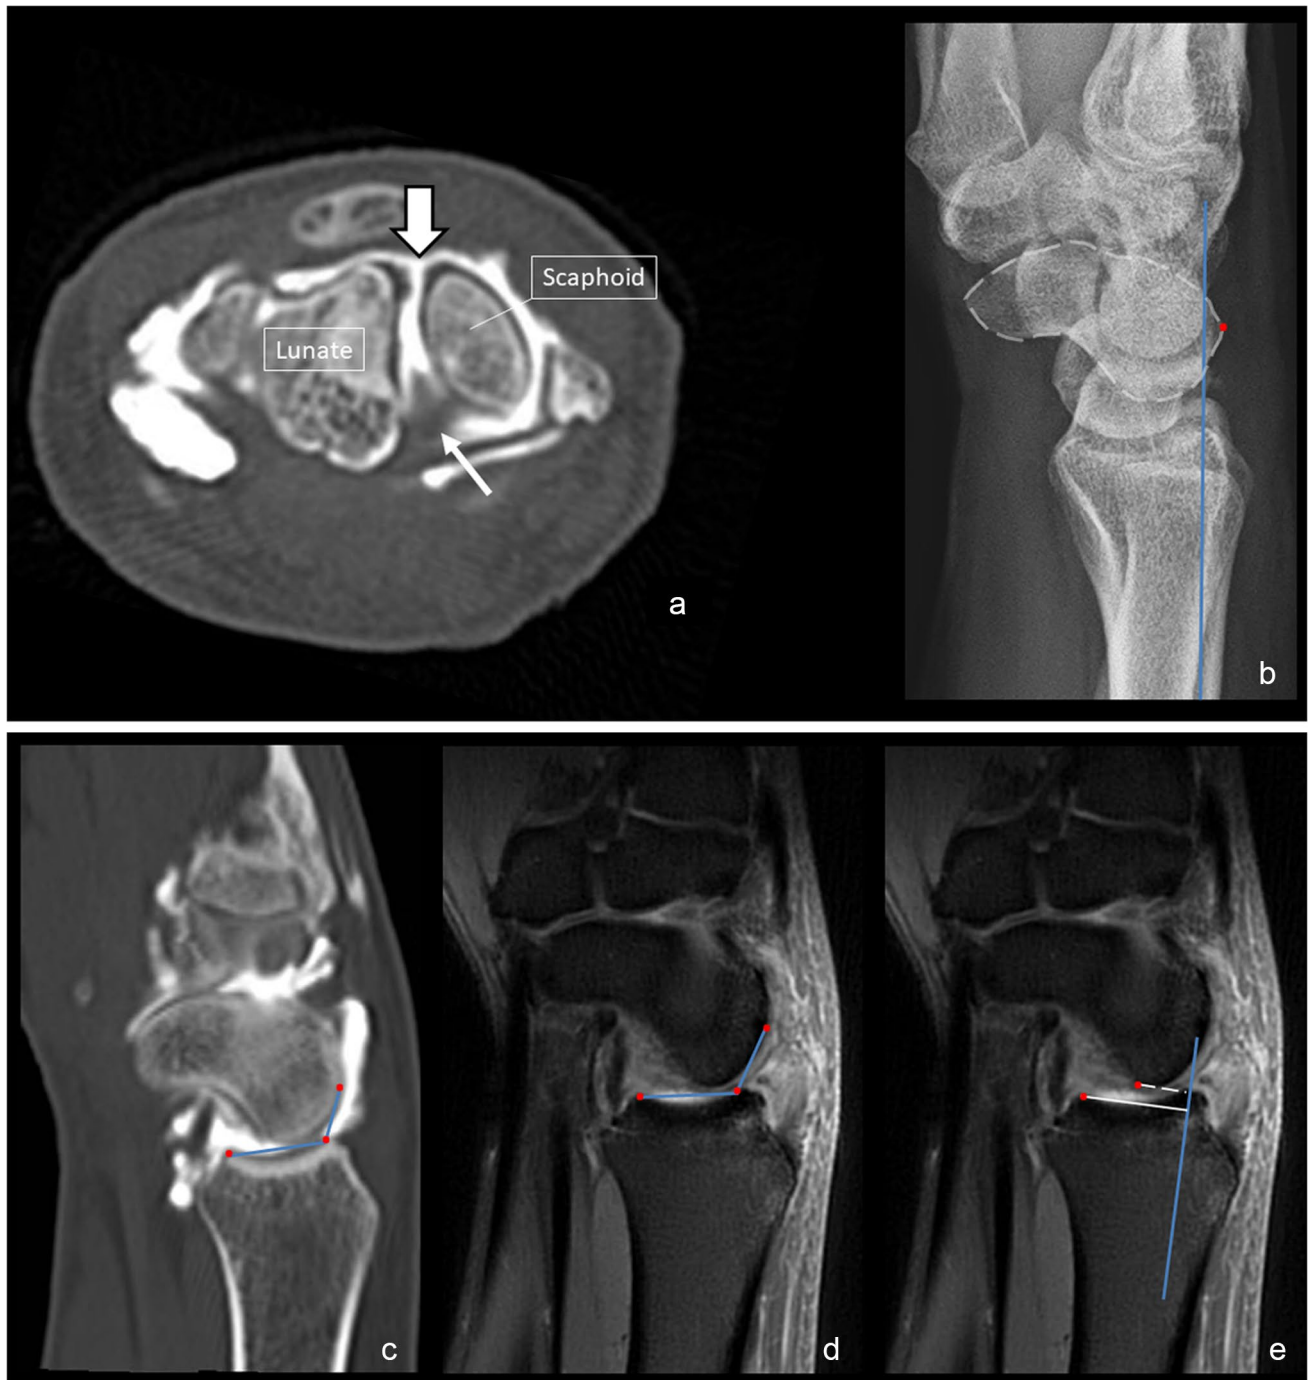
A 44-year-old female with post-traumatic dorsal wrist pain. a Axial CT arthrography image depicting a full tear of the dorsal portion of the scapholunate ligament (fat arrow) and an irregular partially torn aspect of the ventral portion (arrow). b–e The dorsal tangential line (b), posterior radioscaphoid angle on CT (c), posterior
